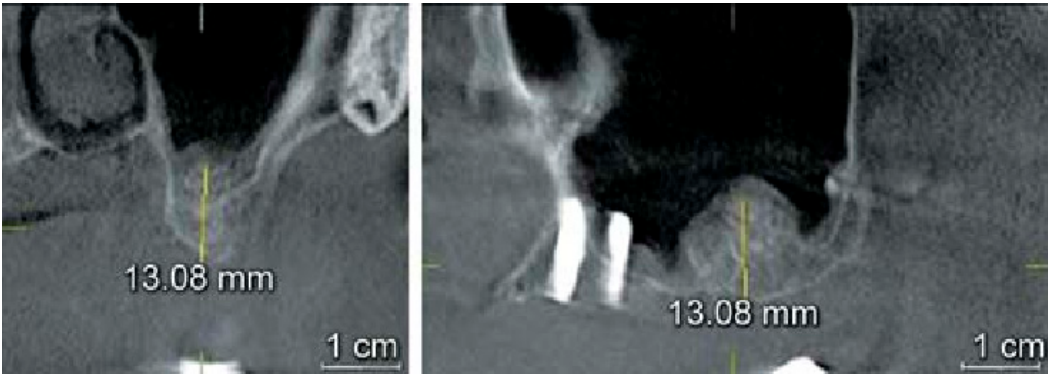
Radiograph 6 months after sinus augmentation demonstrating the new osseous height achieved with sinus elevation and grafting
